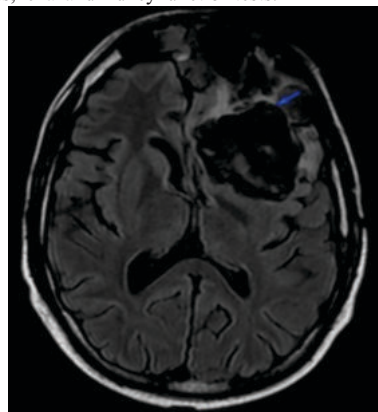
MRI Brain Showing A Large Lobulated Extra-axial Altered Signal Intensity Mass In The Left Frontal Region (Arrow)
